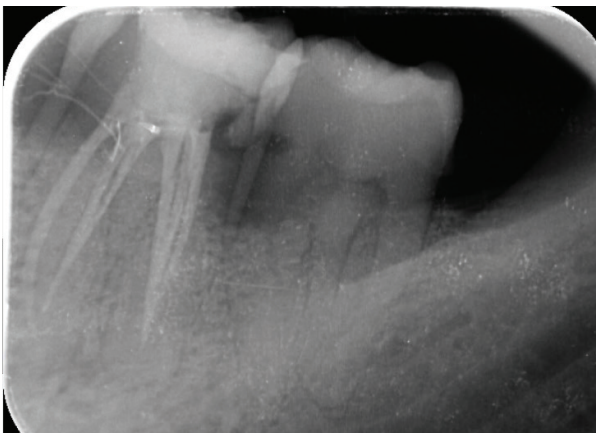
Periapical radiograph taken 1 week post obturation by the bisecting angle technique.
